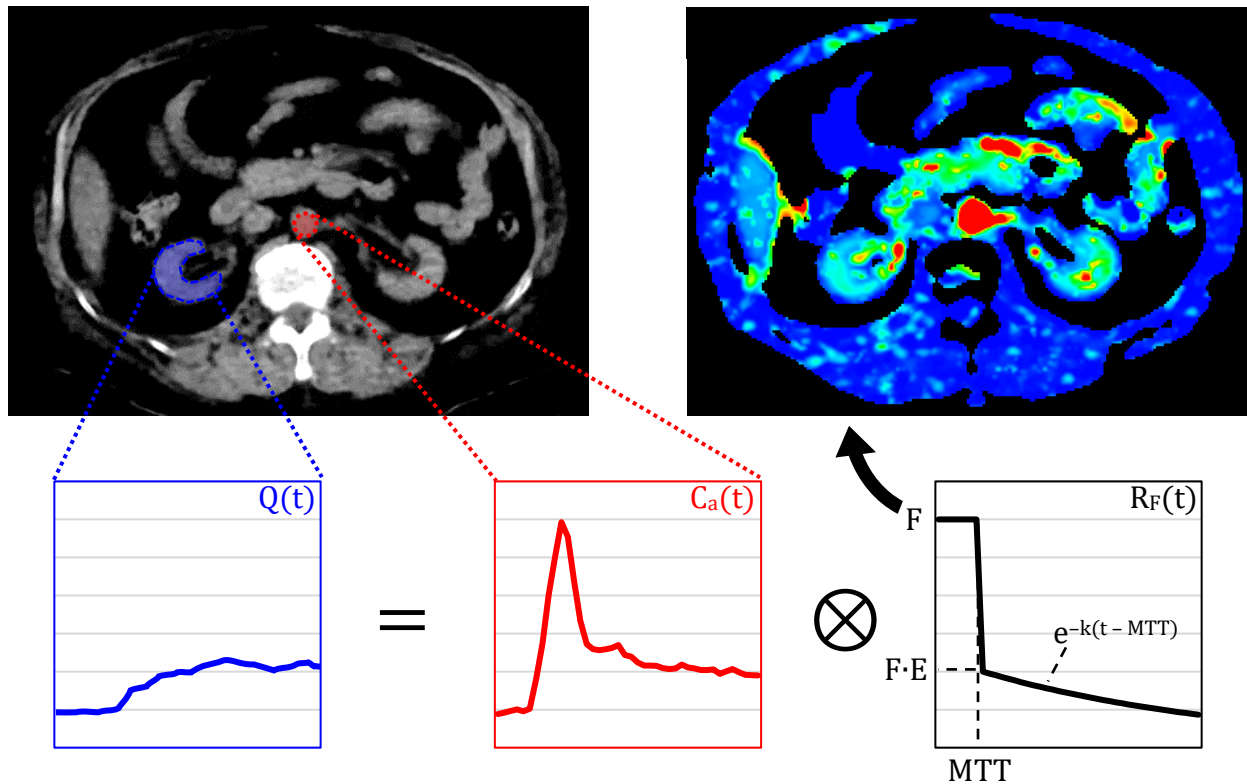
Application of tracer kinetic modelling to the computation of physiologic parameters (e.g., renal blood flow). From the dynamic series CT images, the baseline subtracted arterial TDC is deconvolved from each baseline subtracted tissue TDC (i.e., individual tissue curve for each  $3 \times 3$  pixel block in the CT image) to estimate model (functional) parameters of the flow-scaled impulse residue function (based on non-linear least squares curve fitting), yielding parametric maps (such as blood flow).
